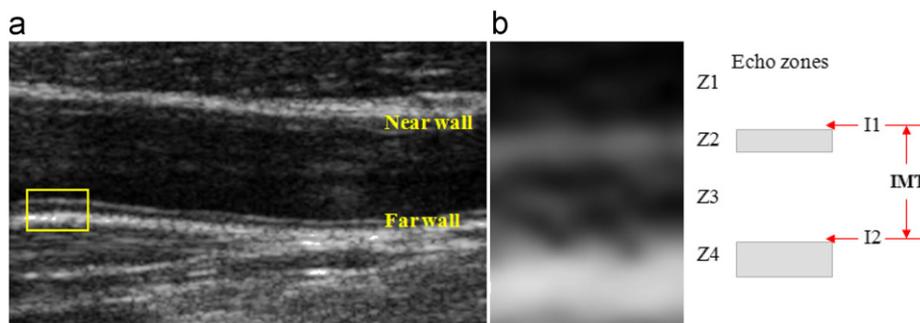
The intima–media complex of the carotid artery: (a) B-mode ultrasound image of the artery and (b) echo zones and interfaces corresponding to the intima–media complex of the far wall of the artery.
